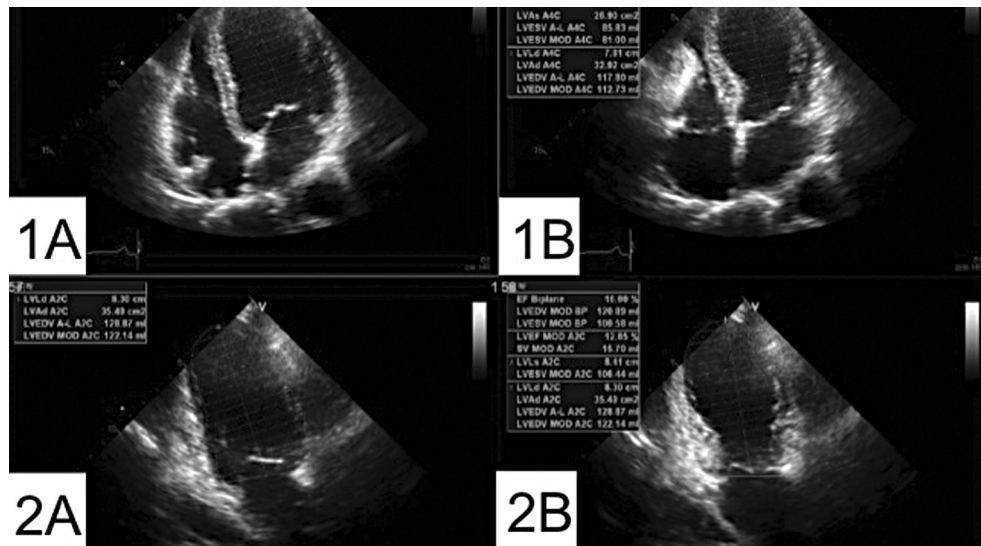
LV EF by Simpson method. This figure shows a calculation of the LV EF by the Simpson method. The 4 chamber and 2 chamber frames at end systole and end diastole are used. The software applications of modern ultrasound machines automatically calculate the LV EF by using the Simpson method, once the ultrasonographer traces the endocardial border. This example concerned a patient suffering from apical ballooning. Only the basal segments were contractile. Panels 1A and 1B are 4 chamber views at end-diastole and end-systole respectively. Panels 2A and 2B show the analogous 2 chamber views.
